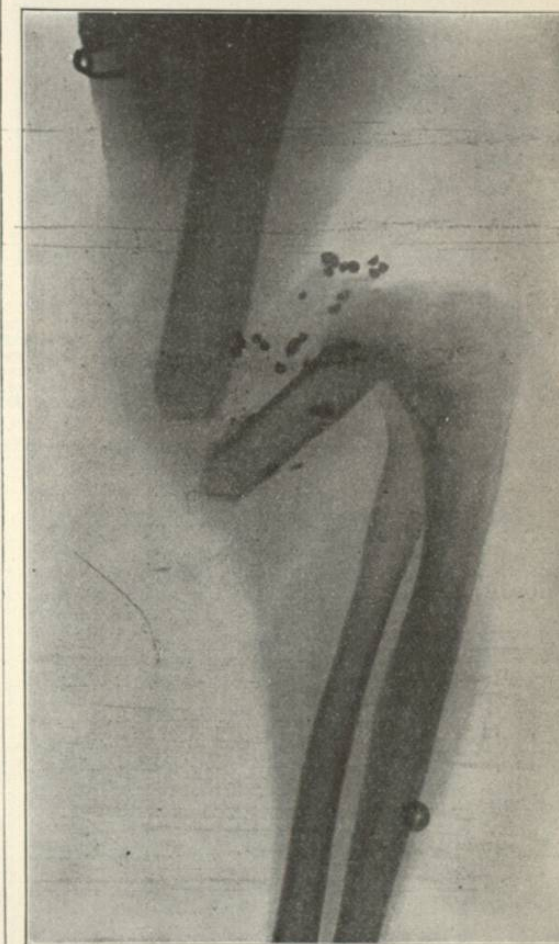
Radiograph. In the case of J. M.—showing ununited fracture of humerus and lodged shot. Wounded June 25th, 1898, by accidental discharge of shotgun within a distance of two feet. Forearm and hand totally paralyzed for three years. Remote effects: flail joint in humerus causing weakness and impairing motion of arm. Radiograph taken October 2d, 1901.
